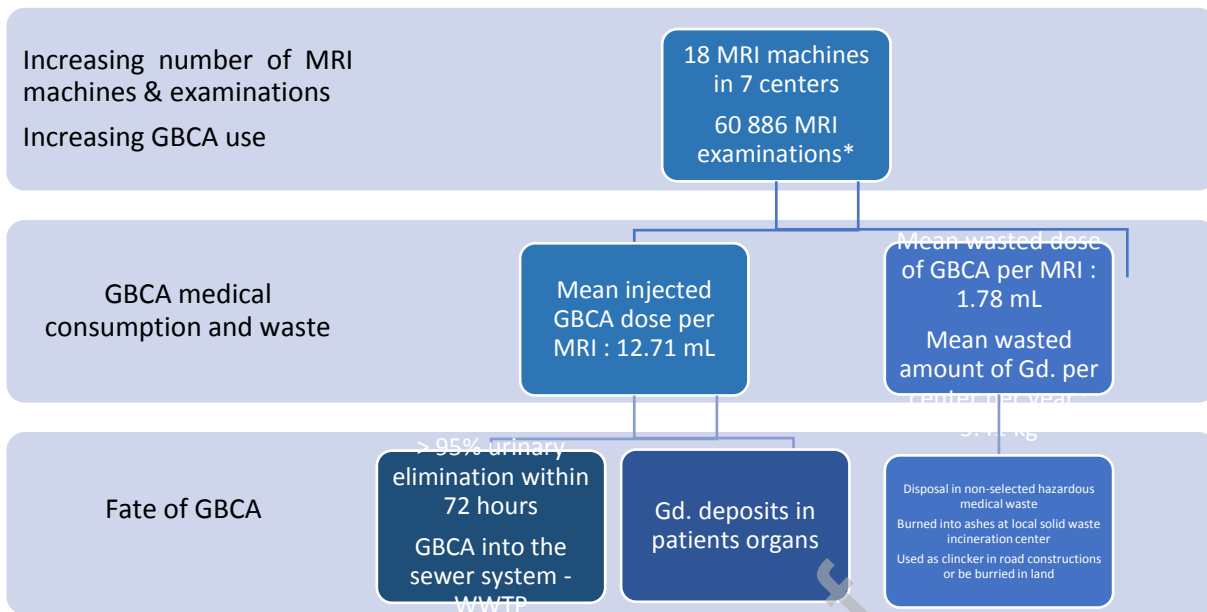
Current challenges in Magnetic Resonance Imaging (MRI) – Gadolinium (Gd)-Based Contrast Agent (GBCA) use and waste management: towards pollution remediation in the environment and water resources.
